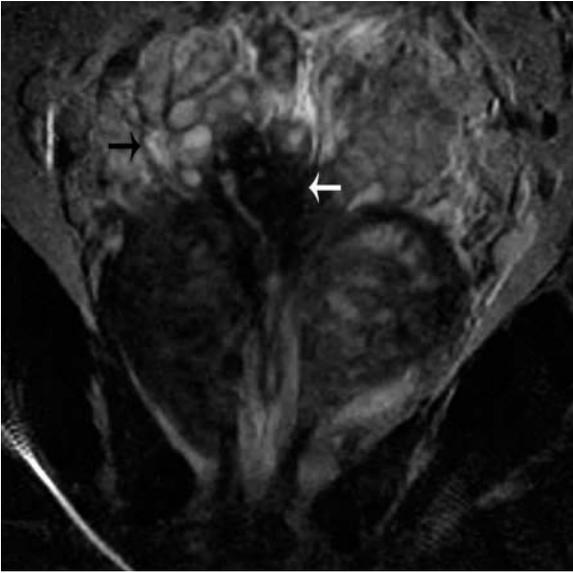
Seminal vesicle invasion of prostate carcinoma in a 72-year-old male. Coronal T2-weighted image reveals diffuse low signal intensity tumor throughout the right side of the gland with extension into the right seminal vesicle (white arrow). A more superior uninvolved portion of the right seminal vesicle is also noted on the right (black arrow).
